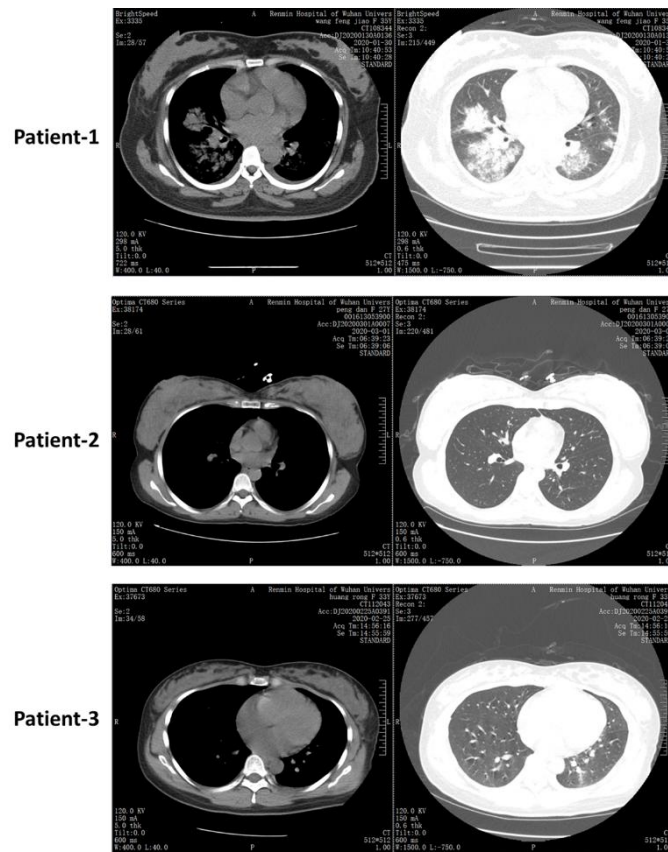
Chest CT scans of three patients. This figure shows patchy consolidation and opacities
